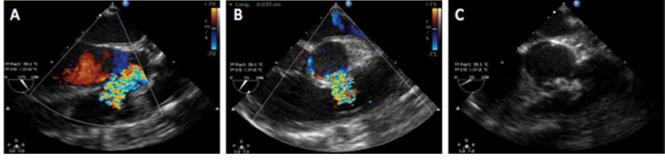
Series of transthoracic echocardiogram images demonstrating the color flow across the ruptured sinus of Valsalva aneurysm from the right coronary sinus into the right ventricular outflow tract in the long (*Panel A*) and short (*Panel B*) axes. (*Panel C*). The Amplatzer Ductal Occluder II is in a good position across the ruptured aneurysm following release.
